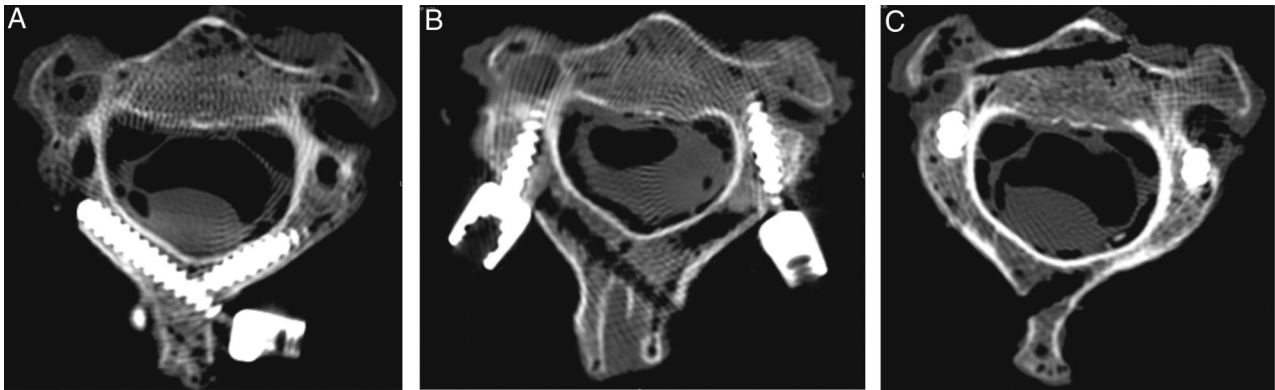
CT scans demonstrating proximity of C2 screws to the vertebral artery. A, Laminar screw technique, B) pedicle screw technique, C) transarticular screw technique.
